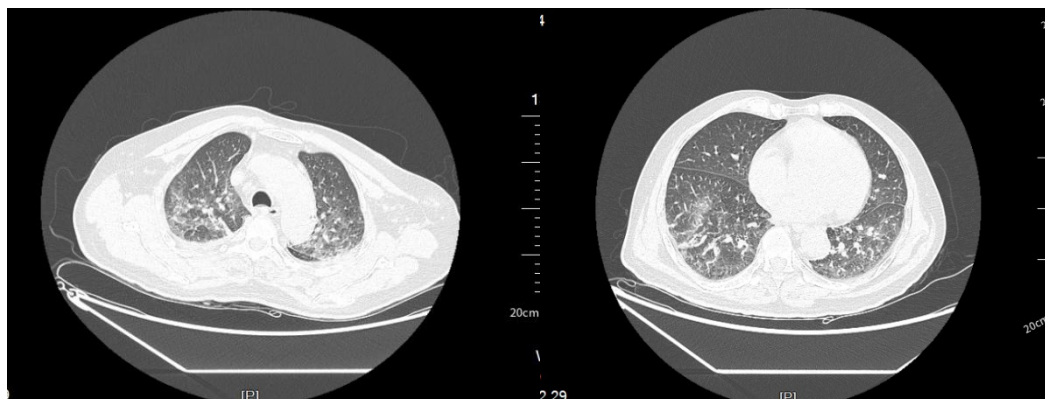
The plain CT scan of the chest shows multiple exudative lesions in both lungs
